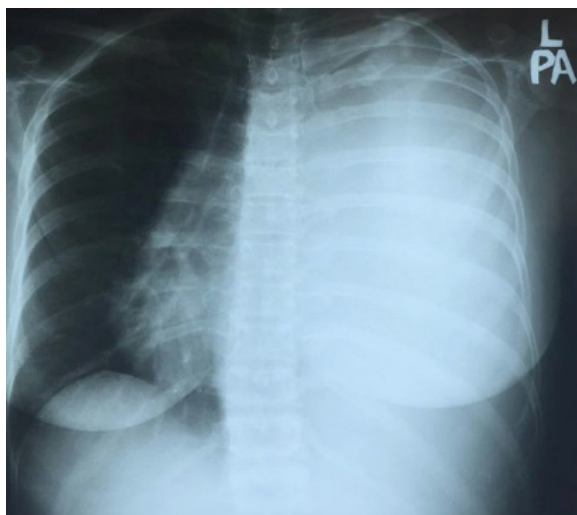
Chest X-ray showed homogenous opacity over the left hemithorax
